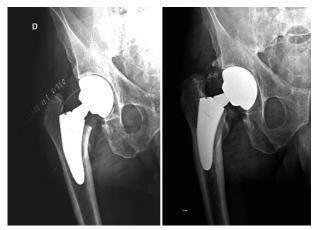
X-rays of a short-stem THA immediately after primary THA and d 5 years later, showing varus tilt of the stem
